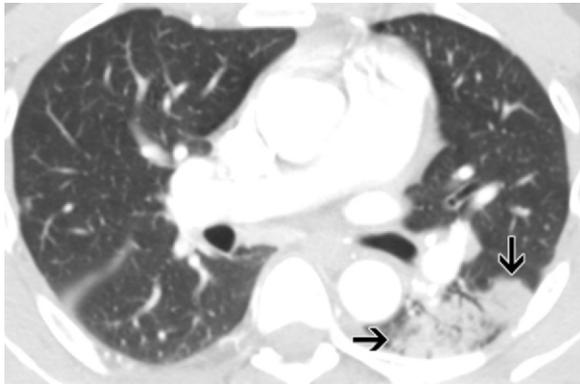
NLH in a 48-year-old man. Axial CT image shows a masslike area of consolidation in the left lower lobe with air bronchograms (arrows).
